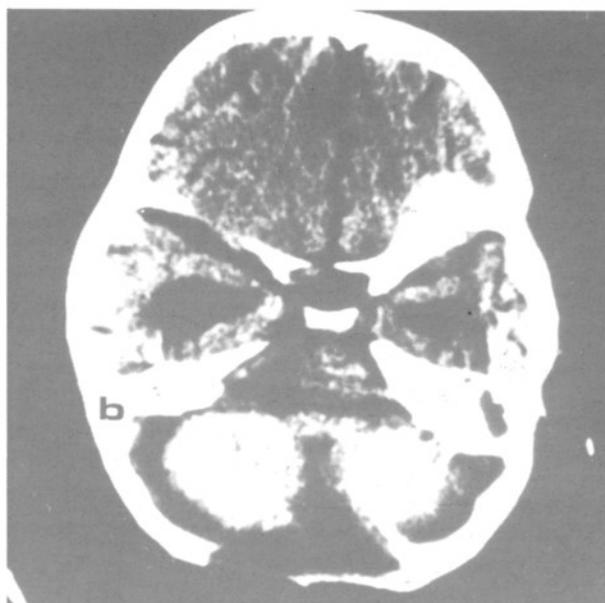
(a) CT scan showing nonhomogeneously enhanced tumor filling the fourth ventricle, (b) note the total tumor removal on postoperative CT scan.
